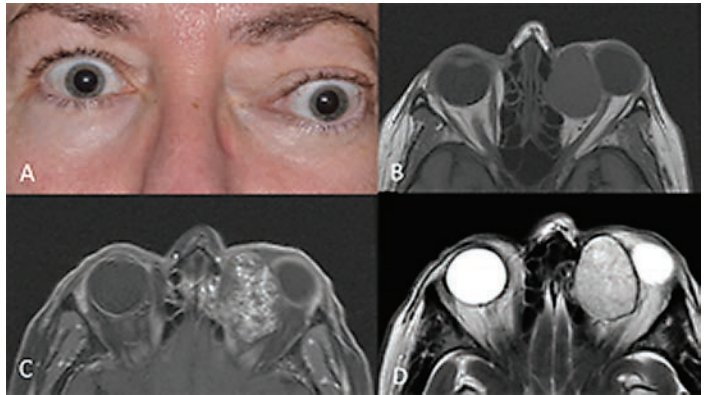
A 53-year-old woman was noted to have (A) left hypoglobus, exotropia and proptosis from an orbital mass superomedially. Magnetic resonance imaging revealed a well-circumscribed orbital mass compressing the globe with (B) low signal on axial T1 imaging, (C) heterogeneous signal on T1 with gadolinium enhancement and (D) slightly heterogeneous signal with crisp margins on T2 imaging.
